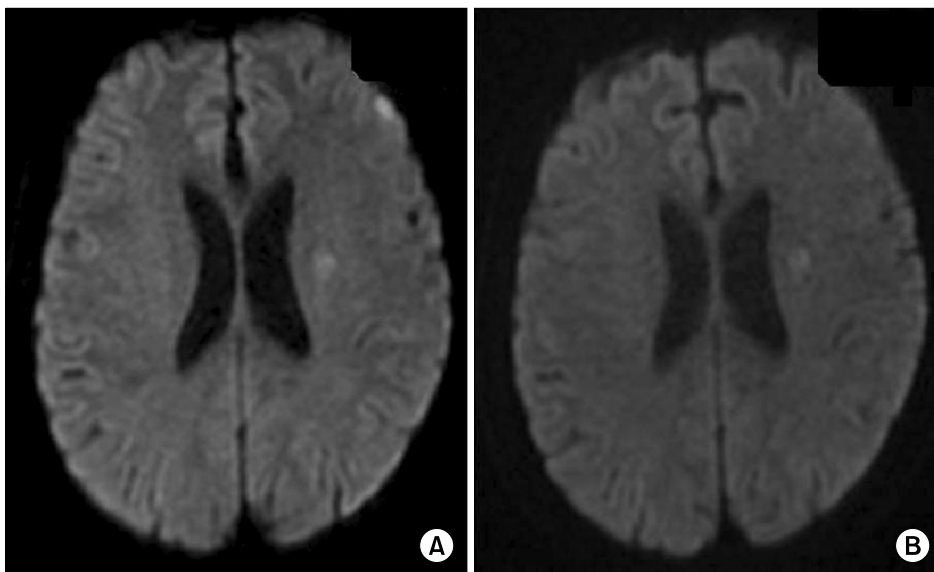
(A) A preoperative DWI image showed acute infarctions in the left frontal cortex and corona radiata. (B) A postoperative DWI image showed mildly decreased signal intensity at the same infarct area. DWI, diffusion-weighted magnetic resonance imaging.
